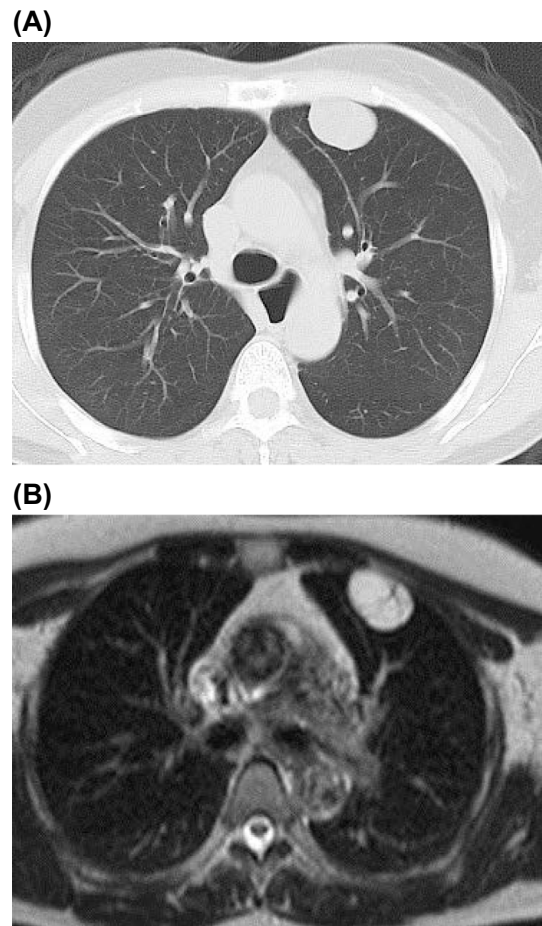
(A) Initial chest computed tomography showed a well-circumscribed high-density mass in the left superior lingular segment. (B) The high-intensity pattern on T2-weighted magnetic resonance imaging indicated a cystic mass.
